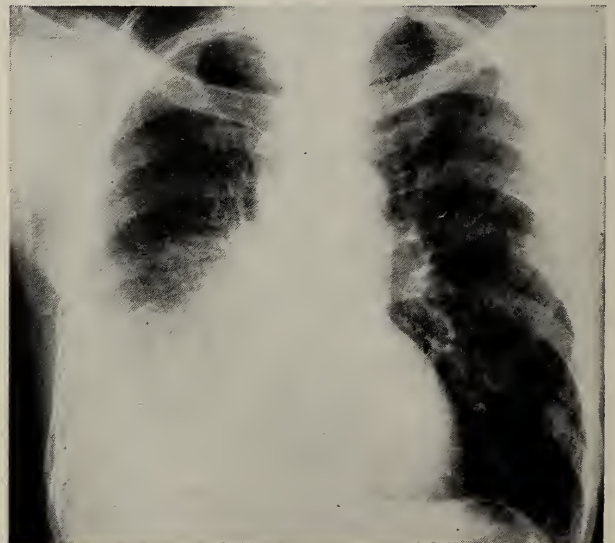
X-ray film of chest of an adult male, showing a large right pleural effusion. Pleural biopsy revealed caseating granulomata and culture of the effusion yielded *M. tuberculosis*.
